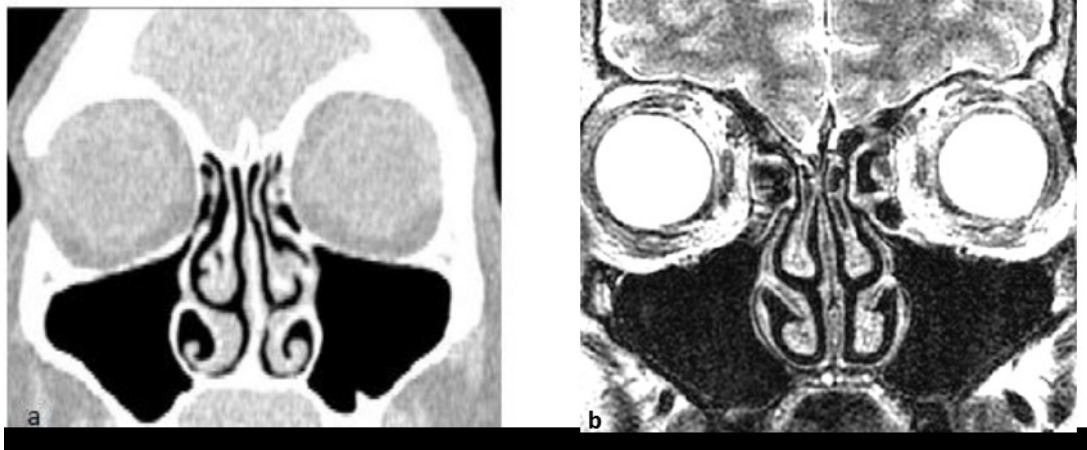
Comparison of a coronal CT (a) and MRI (b) T2 image of a different patient, showing the same area.
